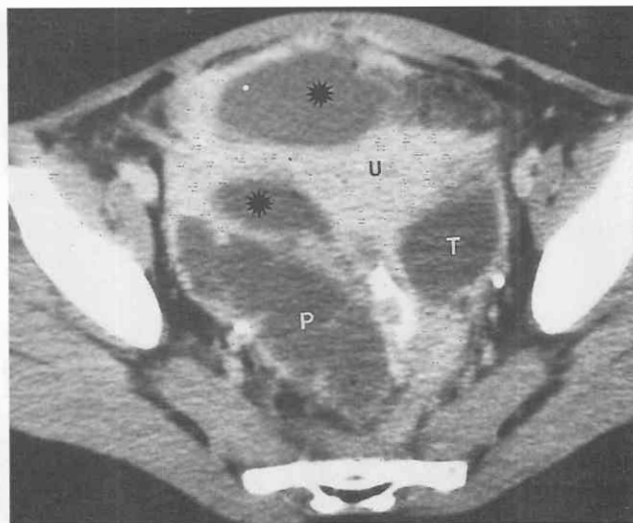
Pelvic inflammatory disease. Contrast-enhanced CT scan in a 17-year-old girl reveals a dilated right fallopian tube consistent with pyosalpinx (P), a round fluid-filled mass in the left adnexal region consistent with a tubo-ovarian abscess (T), and two pelvic abscesses (asterisks). Both lesions were confirmed surgically. The pelvic fat planes are obliterated. U, uterus.
